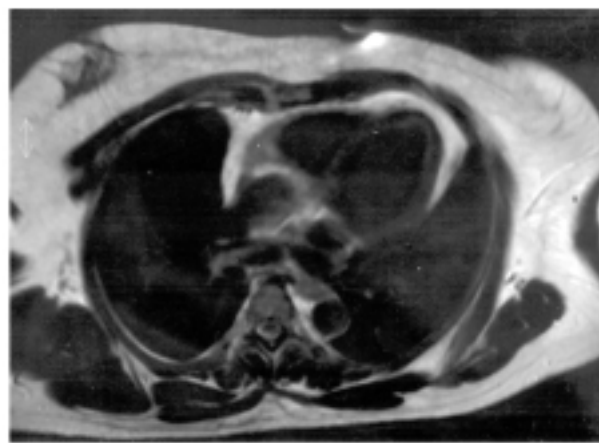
MRI in a patient with peripheral obesity.
